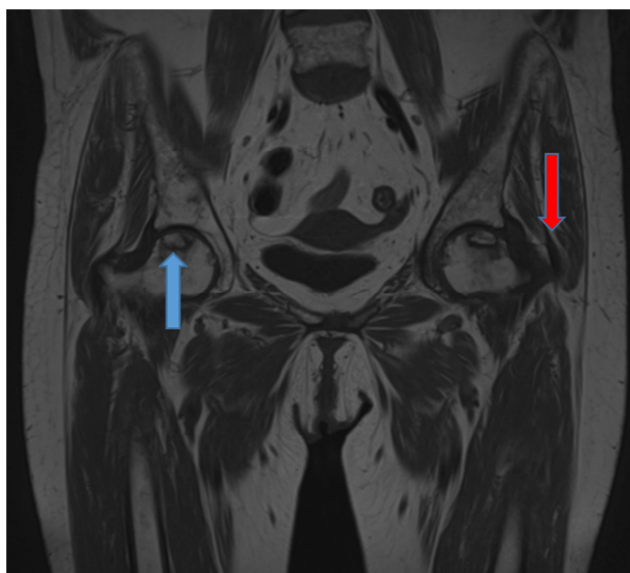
MRI bilateral osteonecrosis of the femoral heads (23). The necrotic area is circumscribed by a T1 hyposignal border. The radiograph showed a stage II of Arlet and Ficat. MRI stages are subdivided into. A: Necrotic area < 15%. B: Necrotic area= 15-30%. C: Necrotic area > 30%.
